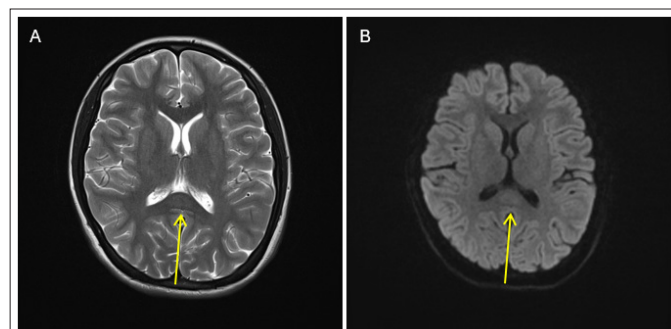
Axial T2 (A) and axial diffusion-weighted imaging (B) on MRI performed 5 days later reveal near complete resolution of the cytotoxic lesion of the corpus callosum (CLOCC) (arrows) seen on the previous examination.
